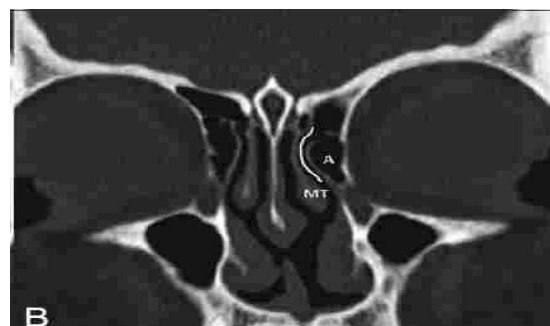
Coronal CT slice at osteomeatal complex level showed agger-nasicells(A)
